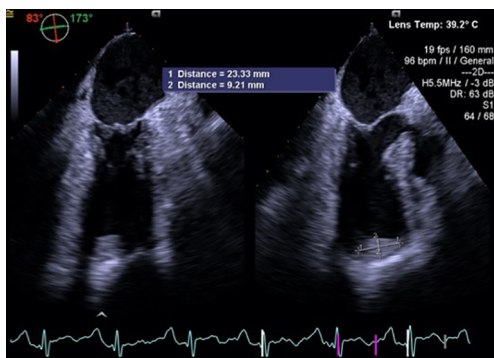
Cardiac ultrasound imaging of the Tako-Tsubo syndrome and thrombus in the right ventricle apex (filled arrow) in case #3.
